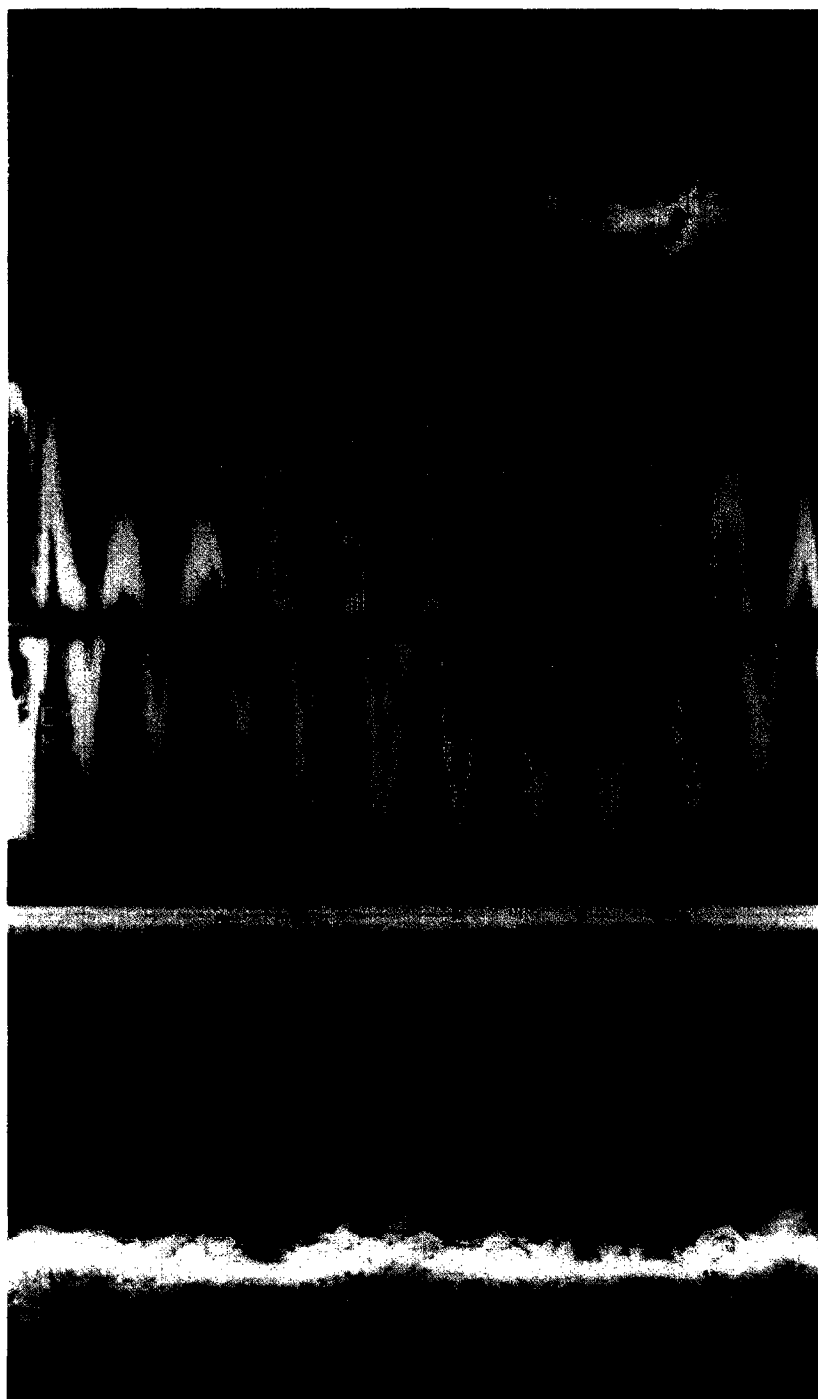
Type II LAA flow pattern with an active "sawtooth" flow profile (*arrows in the upper figure*). The color-coded study across the LAA shows the corresponding bright red emptying and blue filling Doppler flow (*arrows in the lower panel*).
